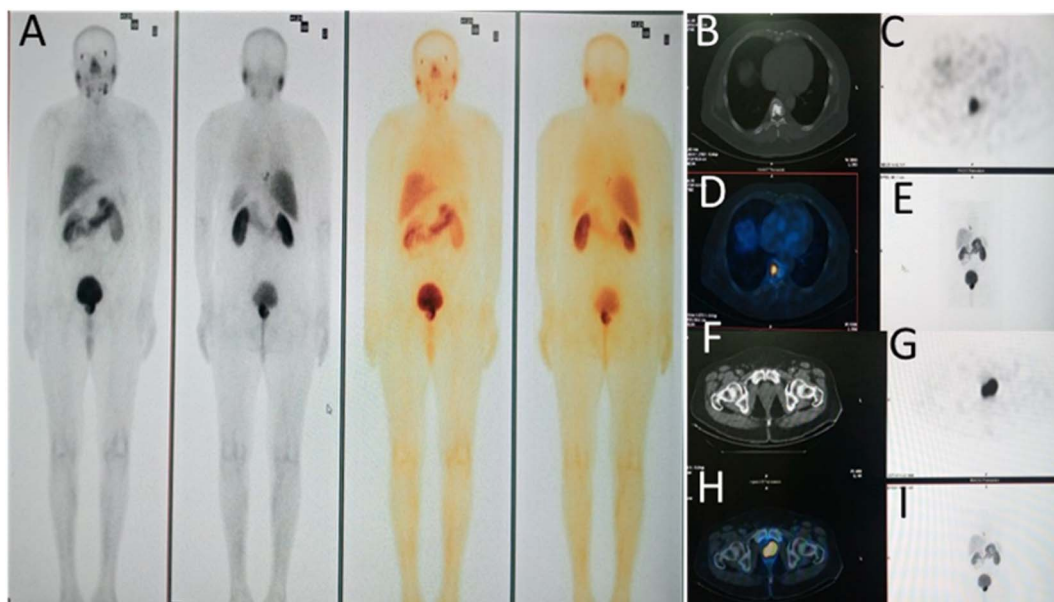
A prostate cancer patient Physiological bio-distribution of $[^{99m}\text{Tc}]\text{Tc-PSMA-P1}$ (A) whole body scan. (B–E) SPECT/CT images showing marked expression of $[^{99m}\text{Tc}]\text{Tc-PSMA-P1}$ in D9 vertebra; consistent with metastasis, (F and G) SPECT/CT images showing marked expression of $[^{99m}\text{Tc}]\text{Tc-PSMA-P1}$ in both lobes of prostate glands, (H and I) SPECT-CT images reveal PSMA avid area involving left median lobe of the prostate gland.
